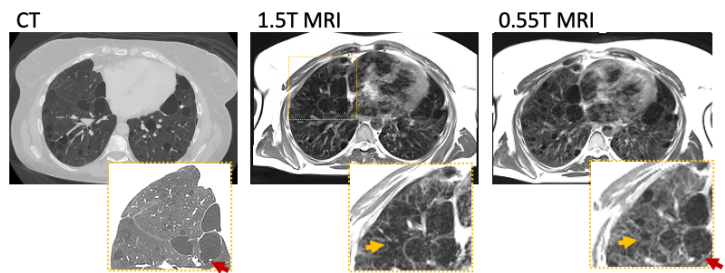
Patient with lymphangioleiomyomatosis imaged with CT, 1.5T MRI and 0.55T MRI. The improved parenchymal signal, cyst delineation (orange arrow) and small details (red arrow) at 0.55T can be appreciated.
